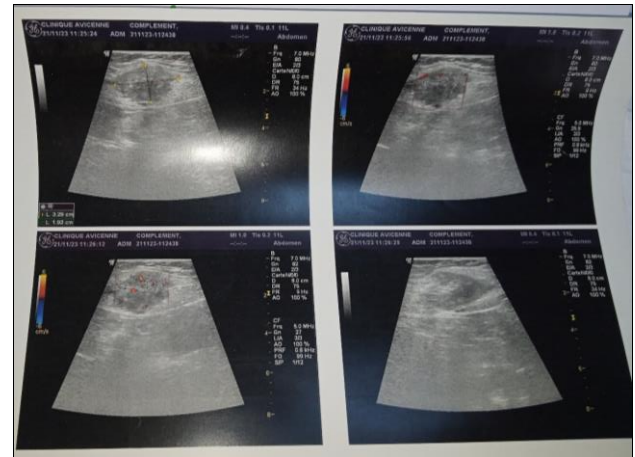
Ultrasound of the tumor
